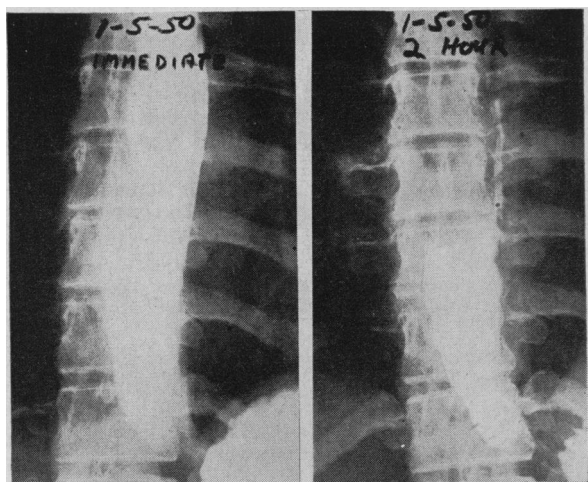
Scleroderma, with esophageal involvement. The patient was a white woman 36 years of age with onset of disease three years previously, and with recent nausea, anorexia and dysphagia. Biopsy of skin showed scleroderma. X-ray examination showed esophageal widening, decreased peristalsis and pronounced delay.
